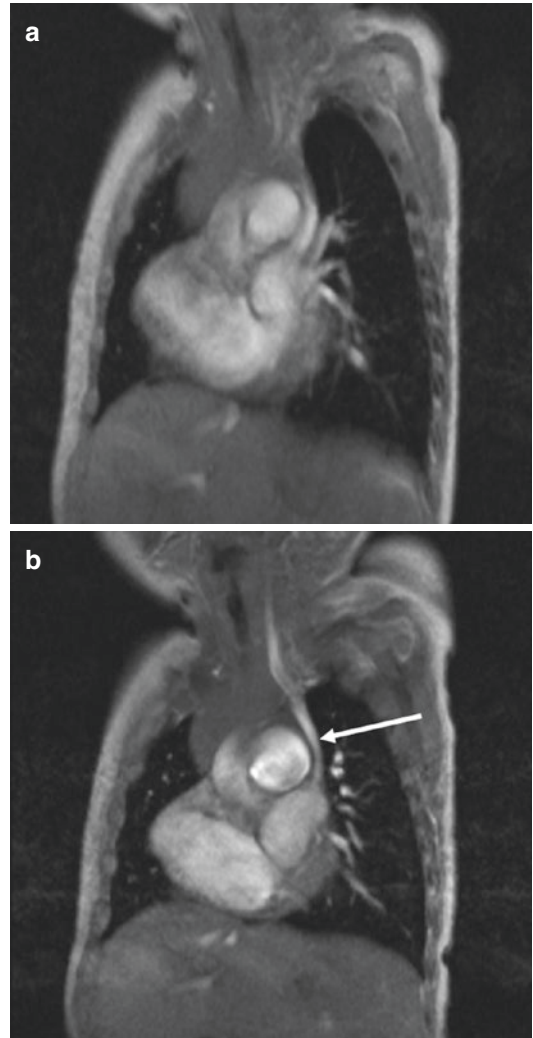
(a), (b) Totally unroofed coronary sinus defect. Sagittal oblique images of cine FLASH MRI sequence show a persistent left superior vena cava (*white arrow*) draining directly into the left atrium due to a complete absence of common wall between the left atrium and the coronary sinus and interatrial communication corresponding to the opening of coronary sinus
